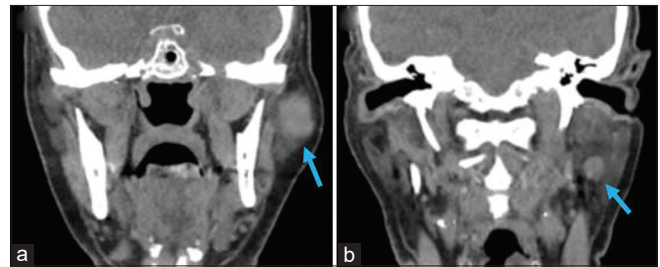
The total body computed tomography with contrast highlighted two hyperdense lumps in the left parotid. (a) One in the pre-auricular region, which was the target (long arrow) of partial parotidectomy electromyographically guided under local anaesthesia without regional block (b) another in the deep lobe (short arrow)
